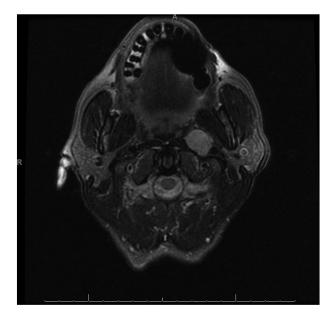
T1 MRI of the head and neck showing an abnormal 2.6 cm left retropharyngeal lymph node.
